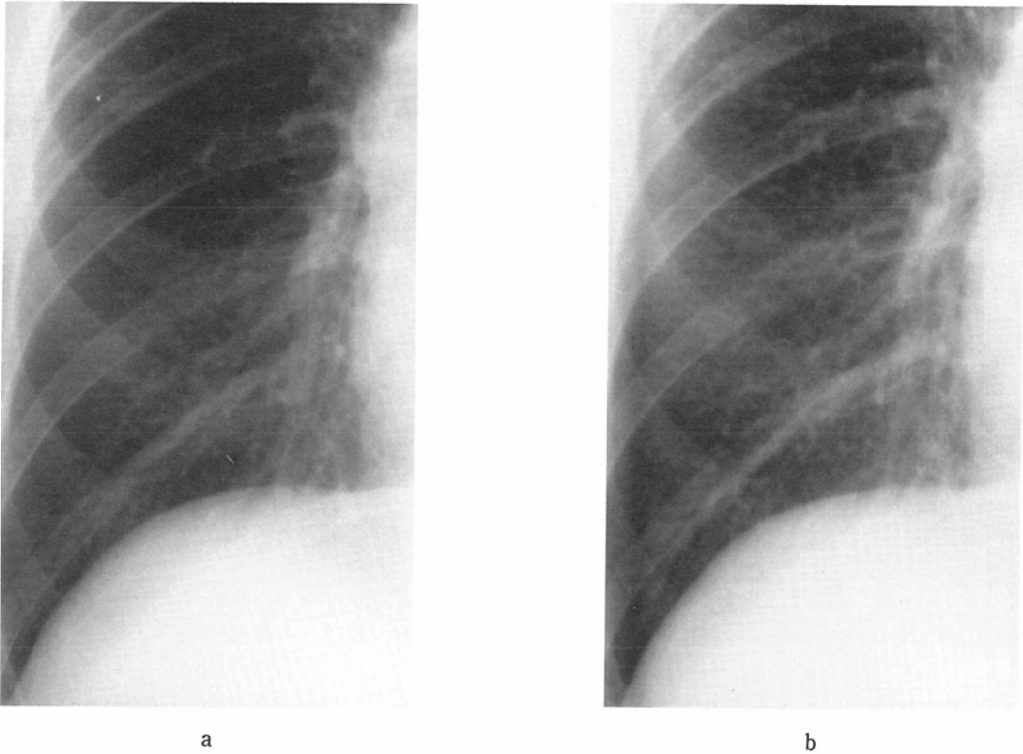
(Case 1) CMV pneumonitis. PA radiograph 1.9 months after cardiac transplantation shows prominent interstitial opacities (b), compared to the normal chest radiograph 5 days before (a).
